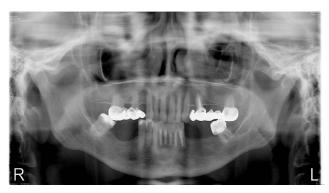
Follow-up orthopantomogram taken 6 years after keratocyst resection and augmentation with a cancellous bone graft harvested from a left tibial tuberosity: Complete bone remodeling within the post-cystic area
